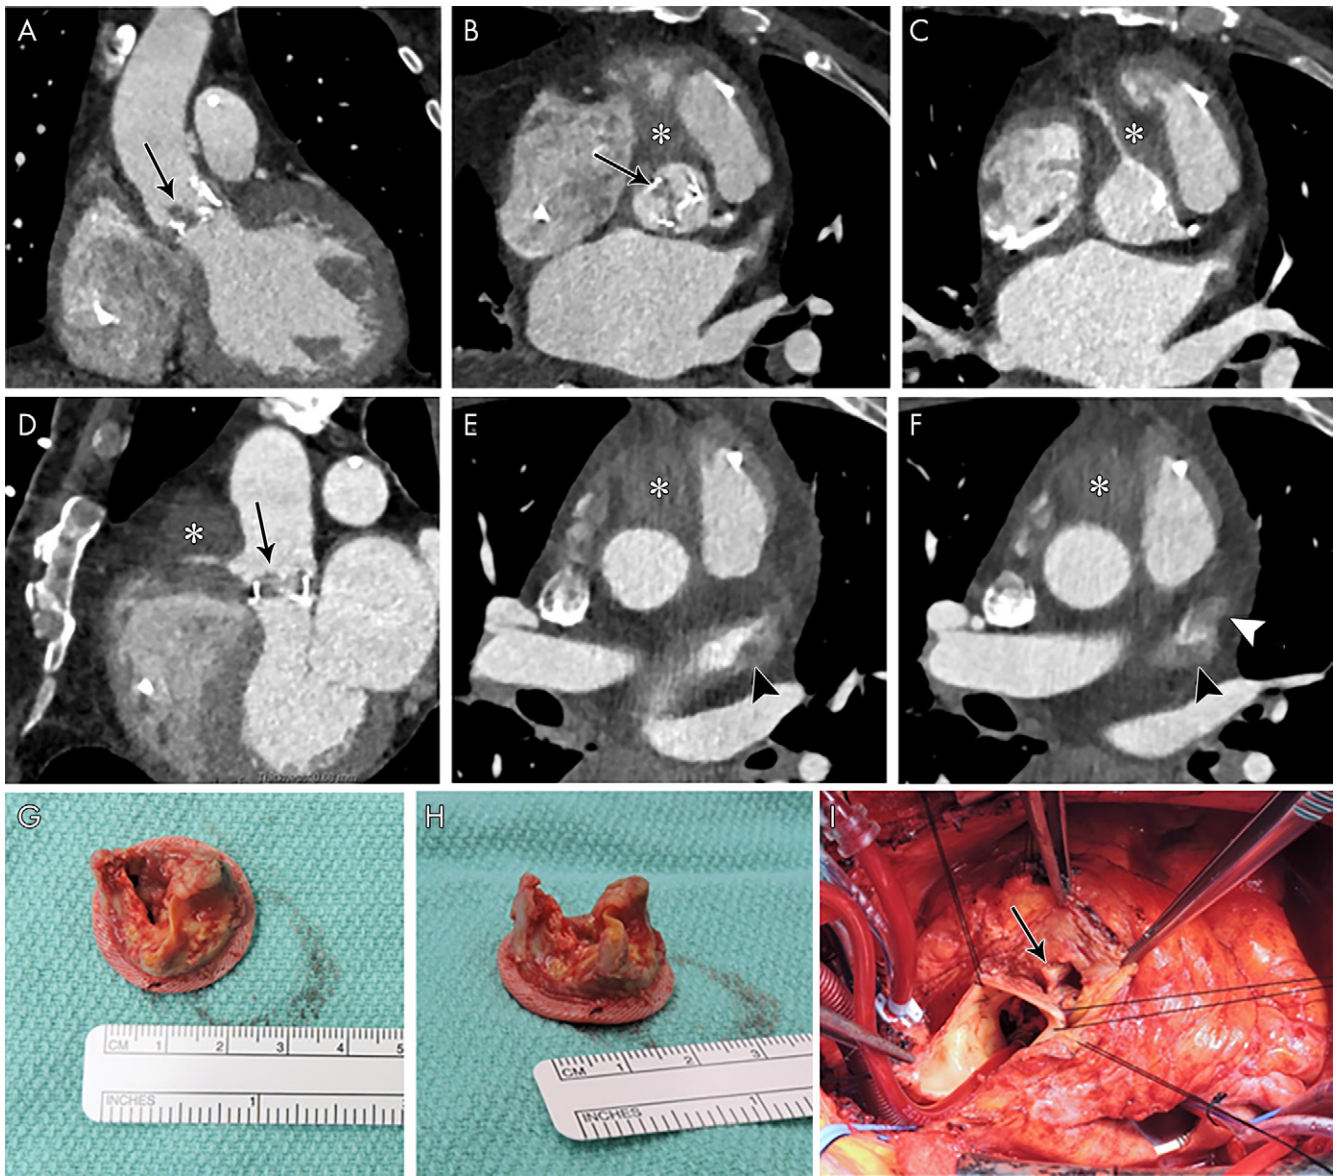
A, Oblique coronal, B, C, short-axis, and, D, oblique sagittal contrast-enhanced CT images through aortic valve and root, and, E, F, axial contrast-enhanced CT images in a 72-year-old man show bioprosthesis leaflet thickening and calcifications with nodular attenuation reflecting vegetation (arrows), ill-defined low-attenuation area (*) anterior to the aortic root and ascending aorta that partially encases the right coronary artery compatible with abscess and phlegmon, and filling defects in the left atrial appendage (arrowheads), suggestive of thrombi (confirmed with transesophageal echocardiography). G, H, Valve vegetations are shown on the excised aortic valve bioprosthesis. I, Intraoperative image shows aortic root abscess cavity (arrow).
